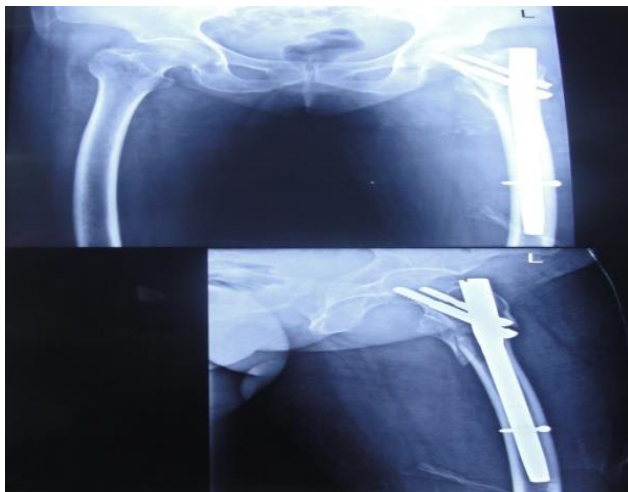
Immediate post-operative X-ray Ap and Lateral view showing good stable fixation achieved by PFN
